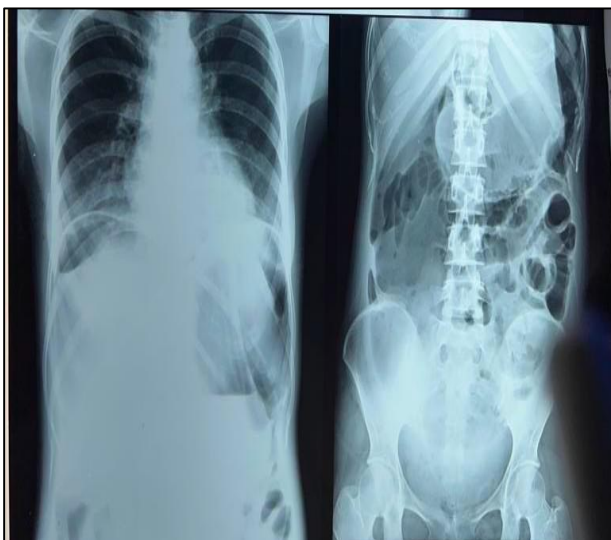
X-ray abdomen showed air under diaphragm and Rigler sign and football sign.
